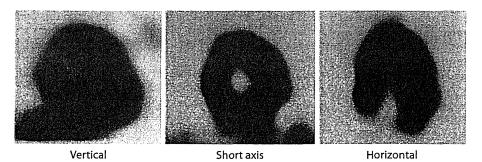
^{99m}Tc-tetrofosmin cardiac muscle scintigram: a perfusion defect of the myocardium was not recognized.
